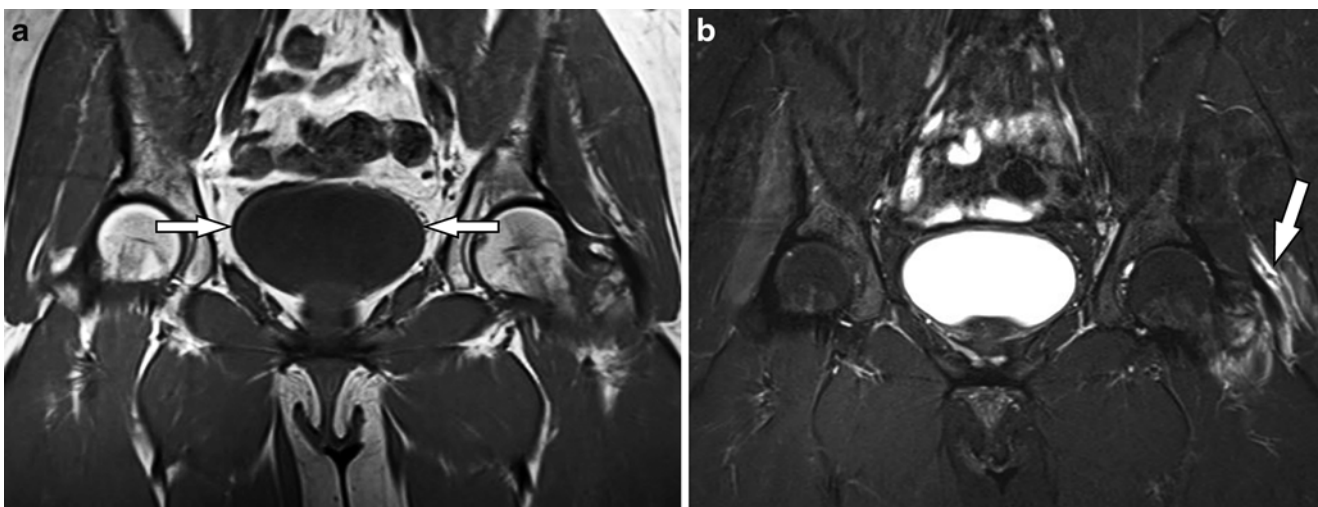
(a, b) Fluid. (a) Coronal T1-weighted image demonstrates low-signal fluid within the bladder (*arrows*). (b) The corresponding coronal STIR (T2W) image reveals increased signal-intensity fluid
